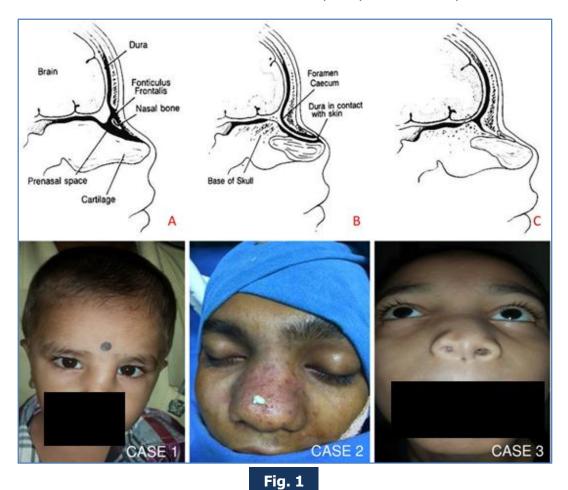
A. Fonticulus frontalis and Prenasal space; B. Clousure of Fonticulus frontalis, formation of Foramen caecum & a projection of dural diverticulum contacts the tip of the nose; C. Retraction of Dural diverticulum and Obliteration of Prenasal space. (Source: Barkovich AJ, et al. Congenital nasal masses: CT and MR imaging features in 16 cases. Am J Neuroradiol 1991; 12:105-16);
